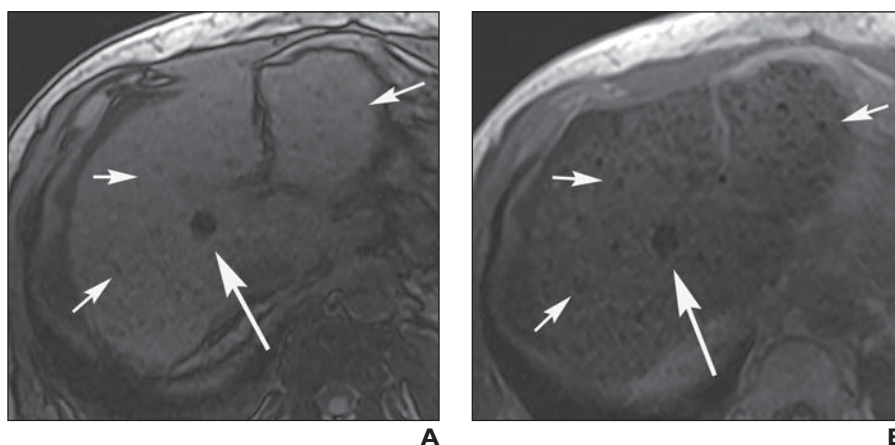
51-year-old man with hepatitis C and siderotic nodules. Multiple tiny areas of diminished signal intensity (*short arrows*) on T1-weighted out-of-phase images exhibit loss of signal intensity or blooming artifact on in-phase images with longer TE. This is typical appearance of siderotic nodules, which are highly visible on T1-weighted fat-suppressed gradient recalled-echo images. Transjugular intrahepatic portosystemic shunt catheter is present with associated blooming artifact (*long arrow*).
